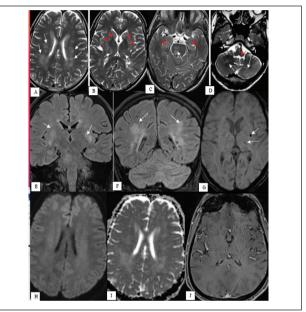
Contrast-enhanced cranial 3T MRI scans. Axial T2w images (A, B, C, D) demonstrate prominent hyperintensities in the periventricular white matter (A, white arrows), bilateral basal ganglia (B, red arrowheads) and thalami (B, white short arros), pons (C, White arrow) and bilaterals medial temporal lobes (C, red arrows), medulla oblongata (D, red arrow) and cerebellum (D, white arrows). Note the sparing of the corpus callosum. These hyperintensities are also shown on coronal fluidattenuated inversion recovery (Flair) images (E, F; white arrows). Axial susceptibility-weighted image (SWI) at the level of basal ganglia and thalami shows blooming artifact in the left putamen and thalamus (G, White arrows). Axial diffusion-weighted image (H; $b = 2000 \text{ sec/mm}^2$) and the corresponding apparent diffusion coefficient (ADC) map (I) show no restricted diffusion . There is no contrast enhancement on the postcontrast T1w image (J).
